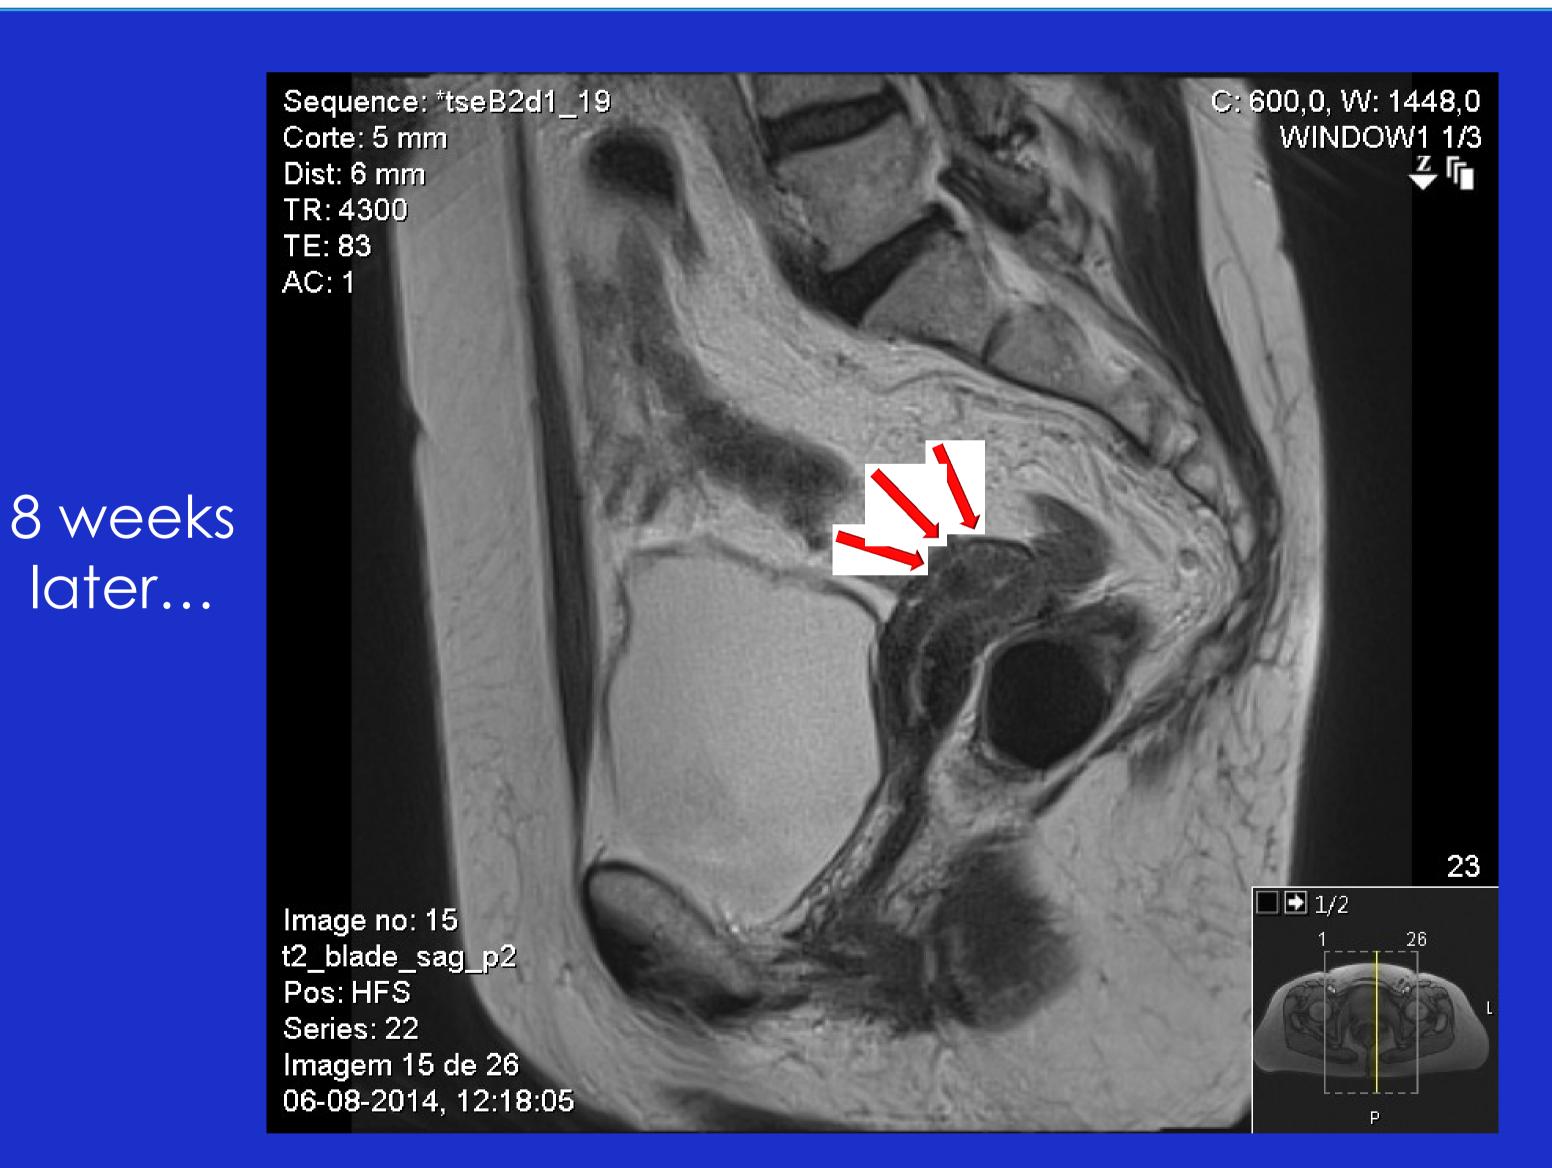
Pelvic MRI in a sagittal plan showing a total regression of the first MRI findings.
